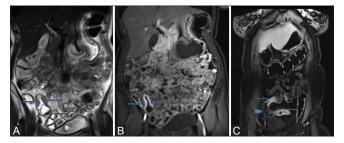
(A-C): (A) Coronal fat-suppressed T2-weighted image showing T2 hyperintense signal within a featureless long segment of small bowel (arrows). Corresponding early postcontrast thin section T1 three-dimensional gradient echo-weighted image (B) shows early post contrast enhancement within the edematous bowel loop, indicating active disease (arrows). (C) Postcontrast thin-section T1-weighted image shows "skip lesions" with hyperenhancement (arrows) and an intervening short segment of normal small bowel in between (arrowhead)
